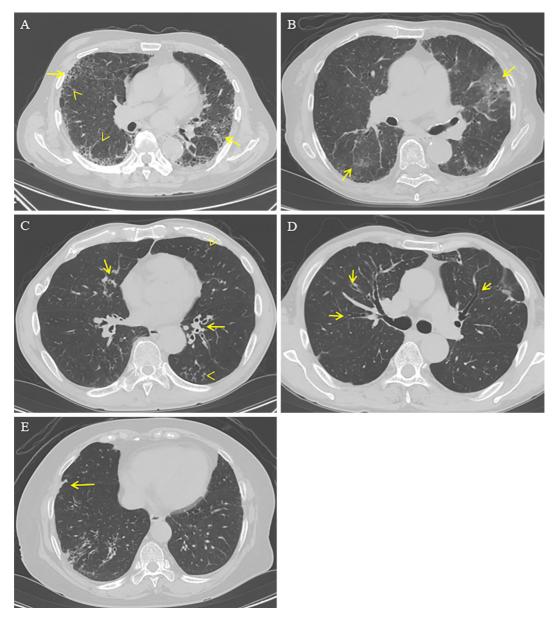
Typical findings of HRCT at the initiation of bDMARDs. A) Lung HRCT of a man (78 years old) with RA-ILD demonstrating reticular shadow (arrows) and fibrosis (arrow heads) in the bilateral lower lobes. B) Lung HRCT of a woman (80 years old) with RA-ILD demonstrating ground-glass opacity (arrows) in the bilateral lungs. C) Lung HRCT of a man (64 years old) with RA-AD demonstrating thickened bronchial walls (arrows) and bronchiolitis (arrowheads). D) Lung HRCT of a man (59 years old) with RA-AD demonstrating bronchodilation (arrows). E) Lung HRCT of a woman (50 years old) with RA-AD demonstrating mucoid impaction (an arrow). Although pulmonary infection was suspected, subsequent bronchoscopy and bronchoalveolar lavage fluid culture revealed no infection. HRCT: high-resolution computed tomography, bDMARDs: biological disease-modifying anti-rheumatic drugs, RA: rheumatoid arthritis, ILD: interstitial lung disease, AD: airway disease
